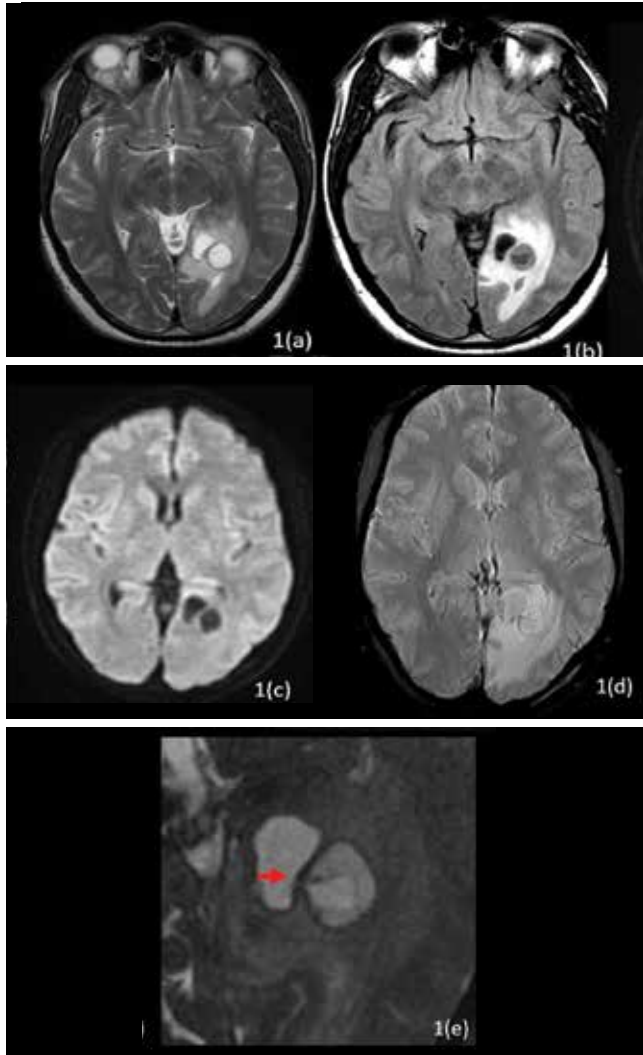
(a) Well-defined bi-lobed T2 hyperintense cystic lesion in the left temporo-occipital lobe with surrounding vasogenic oedema. (b) Medially located cystic component shows complete signal suppression on Fluid-Attenuated Inversion Recovery (FLAIR), whereas the laterally located component shows predominant central signal suppression on FLAIR. (c) No significant diffusion restriction is seen. (d) A few tiny susceptibility foci are seen along the walls of both the cystic components, likely representing calcifications. (e) Axial 3D Constructive Interference in Steady State (CISS) image reveals focal communication between the two cystic components, along with a thin linear membranous structure protruding from the laterally located cystic component (parent cyst) via the defect into the medial cystic component (daughter cyst). Findings suggest rupture of the parent hydatid cyst with resultant daughter cyst formation.
